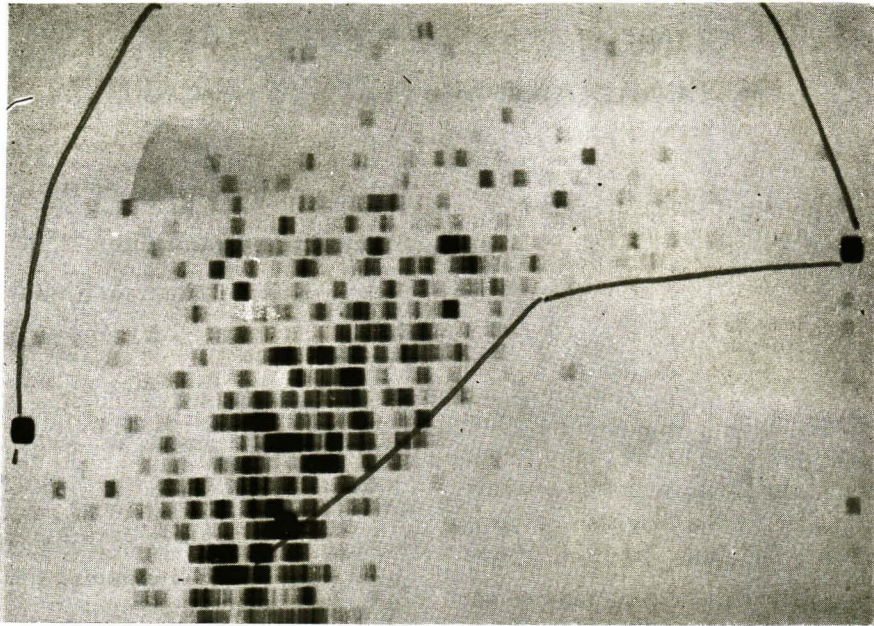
a and b. Normal cisternal scintigram made 3 hours after intrathecal injection of ^{131}I - RISA; a. lateral projection with markers at nasion, mastoid process and external occipital protuberance, b. anteroposterior projection with marker at nasion. The radioactivity is shown in the basal cistern.
